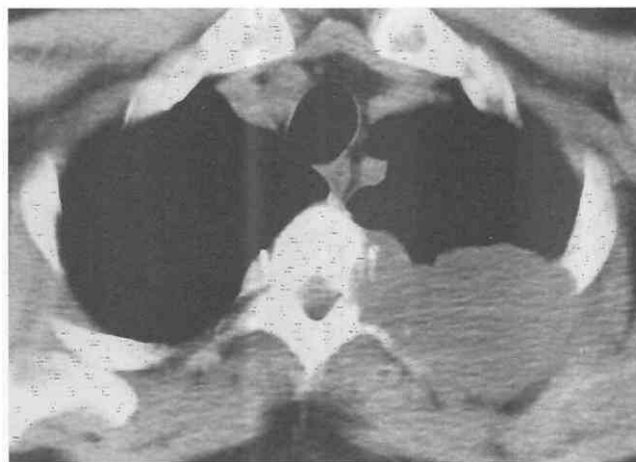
Non-small-cell lung cancer and chest wall invasion. CT scan shows a left upper lobe lung mass with destruction of the adjacent rib and the vertebral body.
